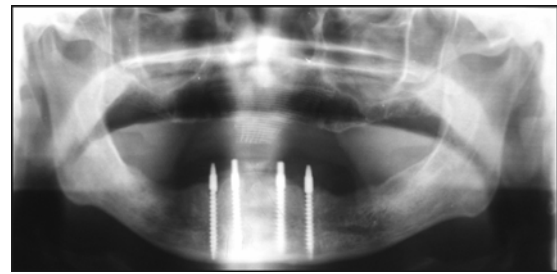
Bicortical implants in X-ray image
